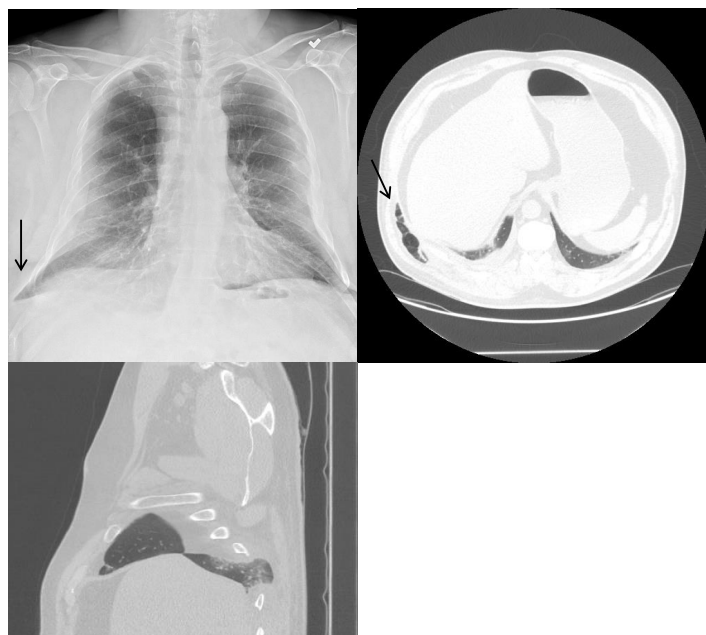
Computed tomography and chest radiograph demonstrating right-sided intercostal lung herniation (arrow).
